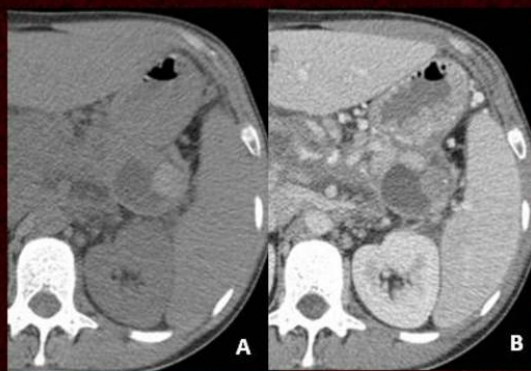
Bleeding pseudocyst in a 37-year-old patient with chronic pancreatitis. (A-B) Images from the axial CT scan show a cystic mass in the pancreatic tail with an internal area of high spontaneous density due to recent hemorrhage. (C-F) The MR study performed in the same patient demonstrated the lesion with high intensity signal on T2-weighted sequences (C), showing hypointense areas consistent with acute hemorrhage. The T1-weighted dynamic study (D-F) reveals a tiny nodular excentric area within the cyst (square in E) following the blood pool signal.
